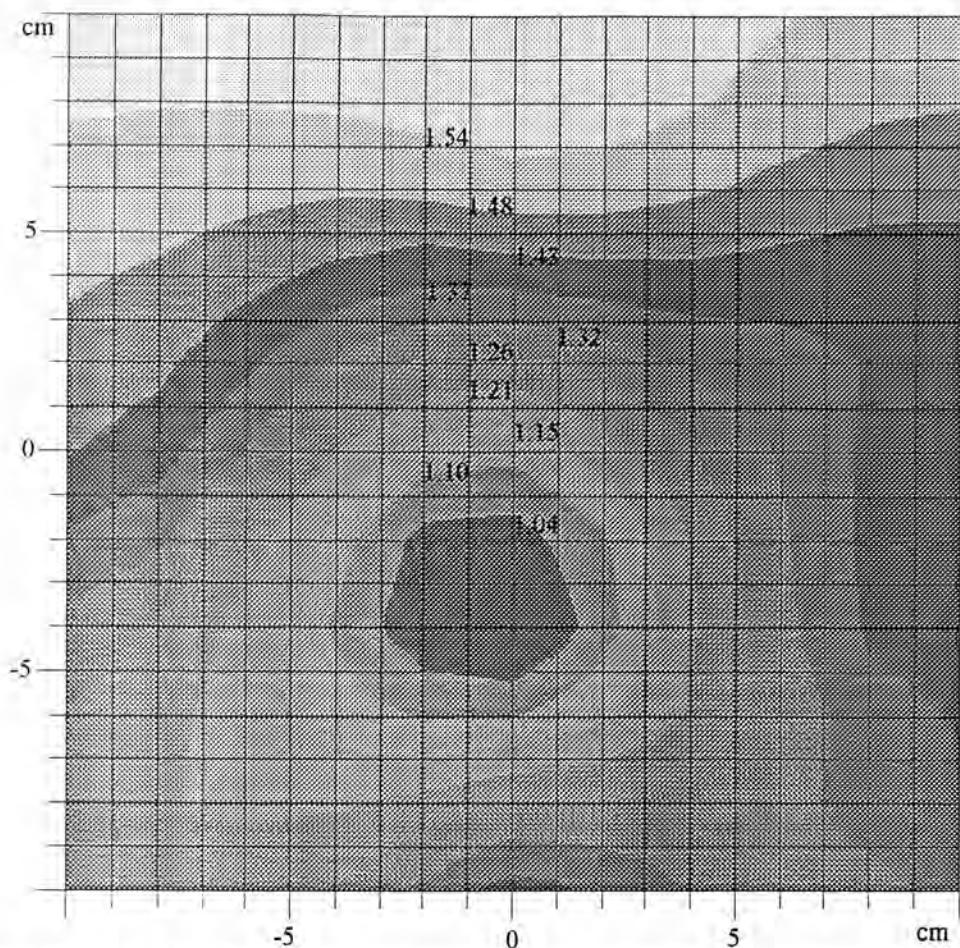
Calculated dose distribution in the representative section (no. 26) of the "abdomen & pelvis" area for the Siemens Somatom Plus CT scanner.
